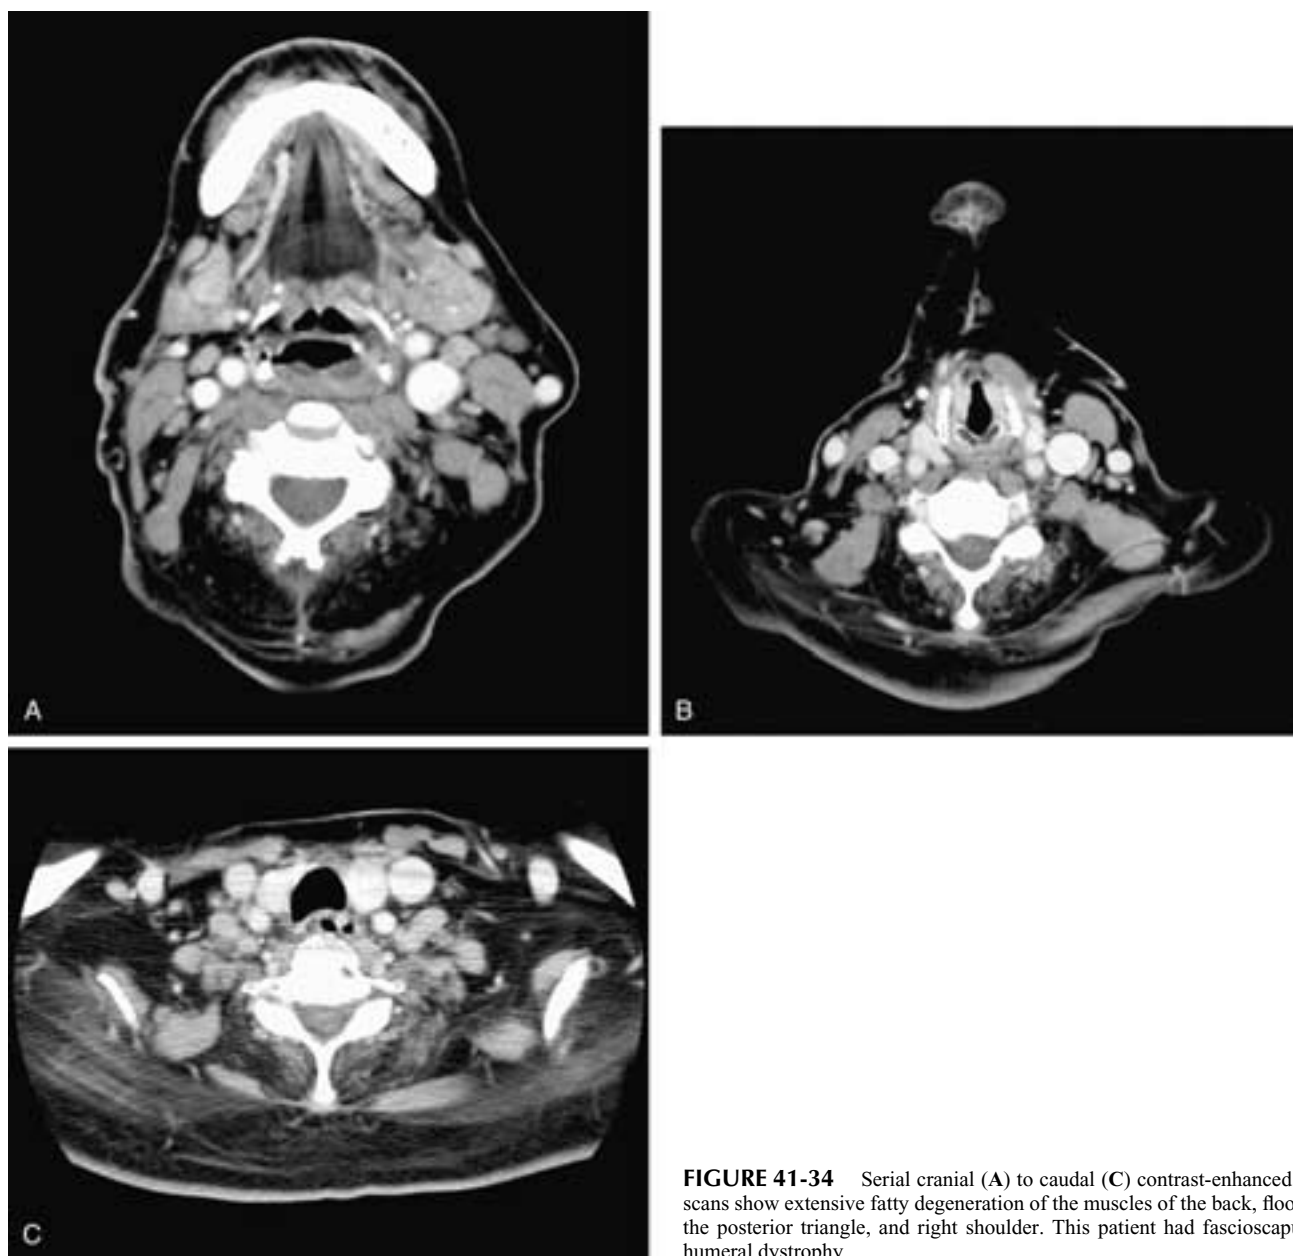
Serial cranial (A) to caudal (C) contrast-enhanced CT scans show extensive fatty degeneration of the muscles of the back, floor of the posterior triangle, and right shoulder. This patient had fascioscapulo-humeral dystrophy.
